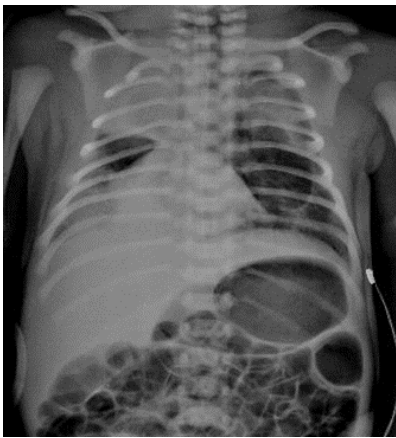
Pneumomediastinal air raising thymus in chest X-ray and loculated air in thorax CT of the second patient
